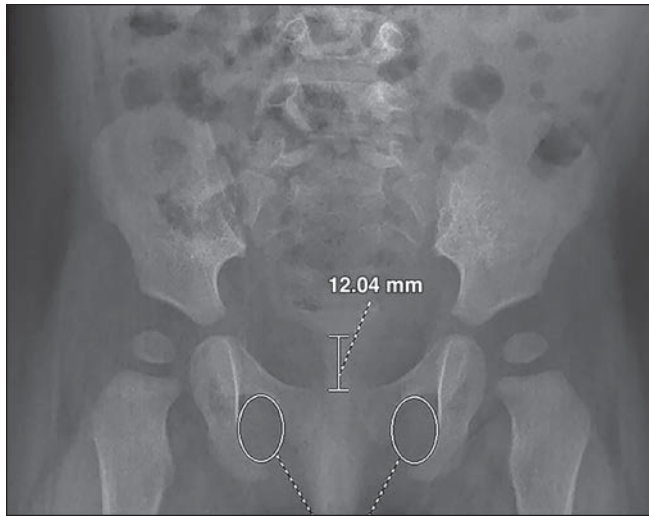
7-month-old healthy girl with very mildly shallow acetabulum bilaterally. Anteroposterior pelvic radiograph depicts criteria used to determine high quality. Coccyx is in line (solid line) with symphysis pubis. Iliac wings, teardrops, and obturator foramina (ovals, bottom dashed lines) are symmetric. Distance between inferior tip of coccyx and pubic symphysis measures 1–3 cm (top dashed line).
